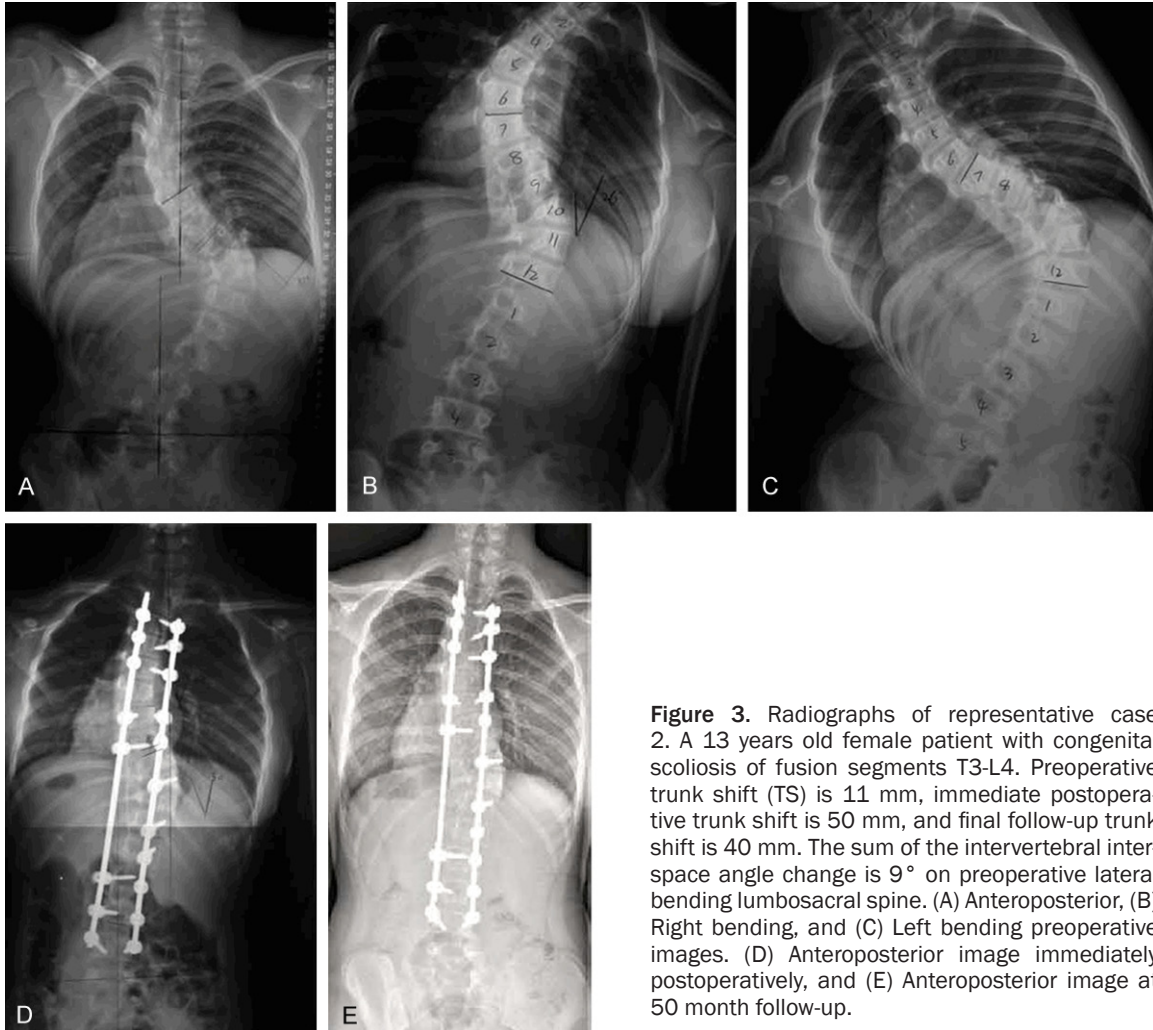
Radiographs of representative case 2. A 13 years old female patient with congenital scoliosis of fusion segments T3-L4. Preoperative trunk shift (TS) is 11 mm, immediate postoperative trunk shift is 50 mm, and final follow-up trunk shift is 40 mm. The sum of the intervertebral interspace angle change is 9° on preoperative lateral bending lumbosacral spine. (A) Anteroposterior, (B) Right bending, and (C) Left bending preoperative images. (D) Anteroposterior image immediately postoperatively, and (E) Anteroposterior image at 50 month follow-up.
